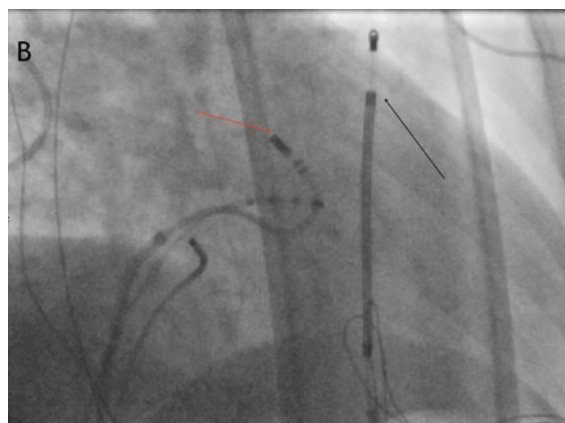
Fluoroscopic image of catheter positions during successful ablation of the PVC from the endocardial LV at the anterior mitral annulus. The red arrow indicates the tip of the ablation catheter using the reverse S-curve technique described by F. Ouyang et al., the black arrow indicates the defibrillation lead of the subcutaneous ICD at the left parasternal border (RAO 30°).
